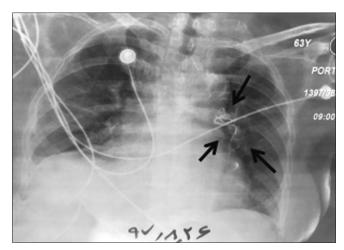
Portable chest radiograph shows a serpentine-like cement embolism in a pulmonary artery branch (black arrows).
